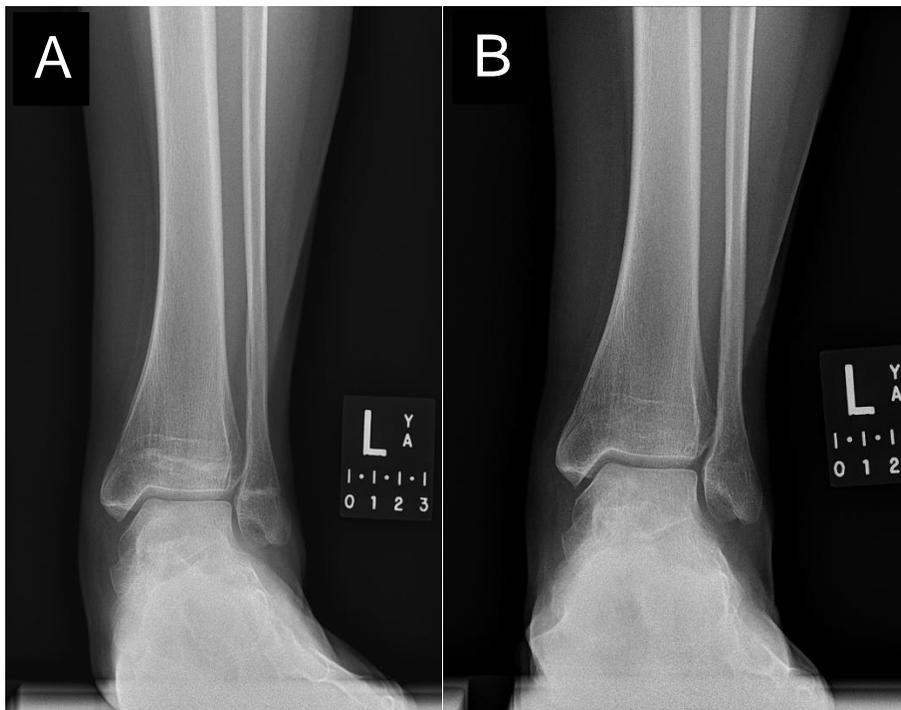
Post-operative A) 14 month and B) 24-month plain film radiograph showing the healing progress to the previous medial talar dome OCD.
